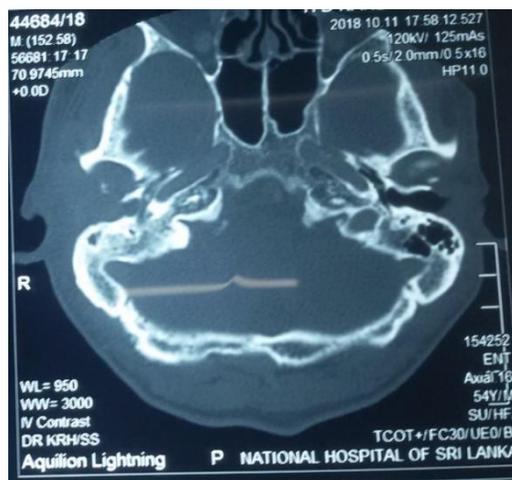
Axial CT window shows soft tissue filling the EAC, middle ear and mastoid
